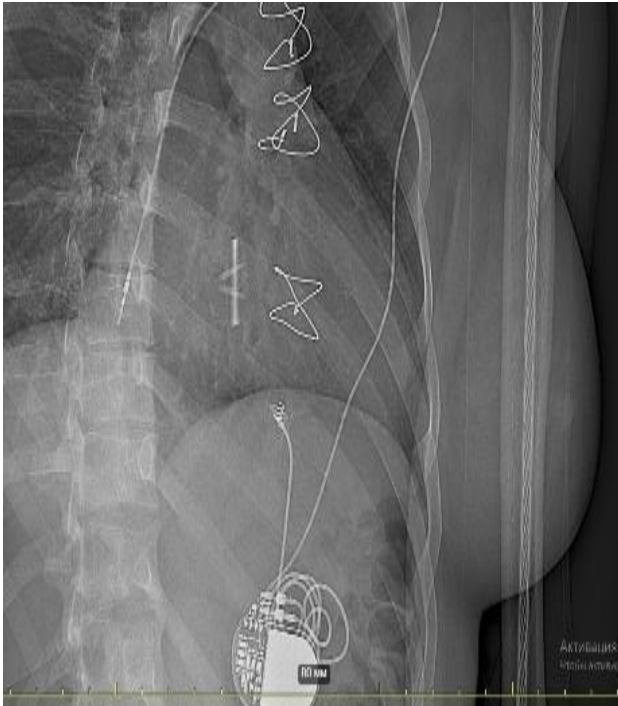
Dislocation of the atrial electrode on X-ray.
